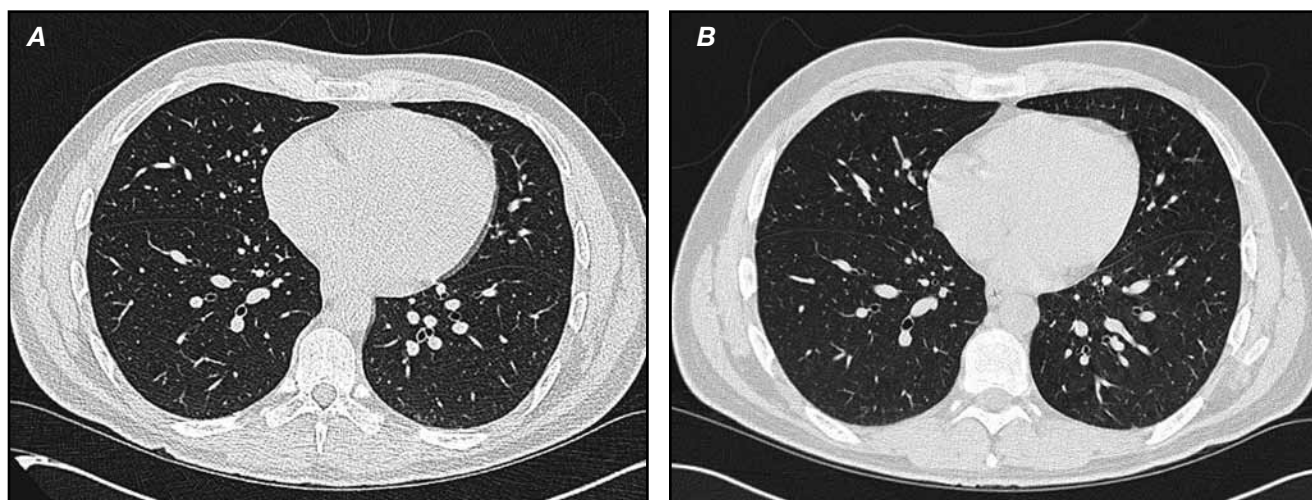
(case 2). Computed tomographic images of lung midzones before (A) and after (B) thyroxine replacement in a 26-year-old man with severe hypothyroidism.
